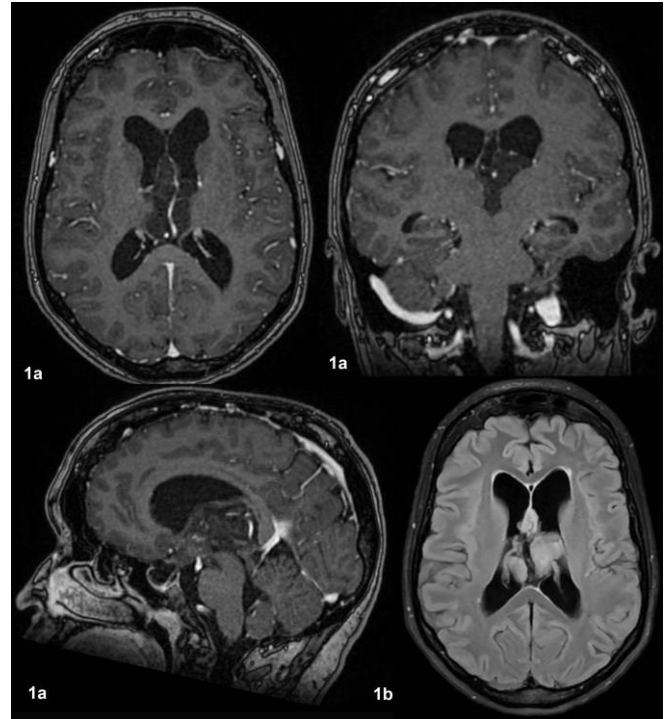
Preoperative brain MRI showing a cystic mass in the third ventricle, measuring approximately $4.6 \times 2.7 \times 4.0$ cm, with indirect signs of mild intracranial hypertension.
